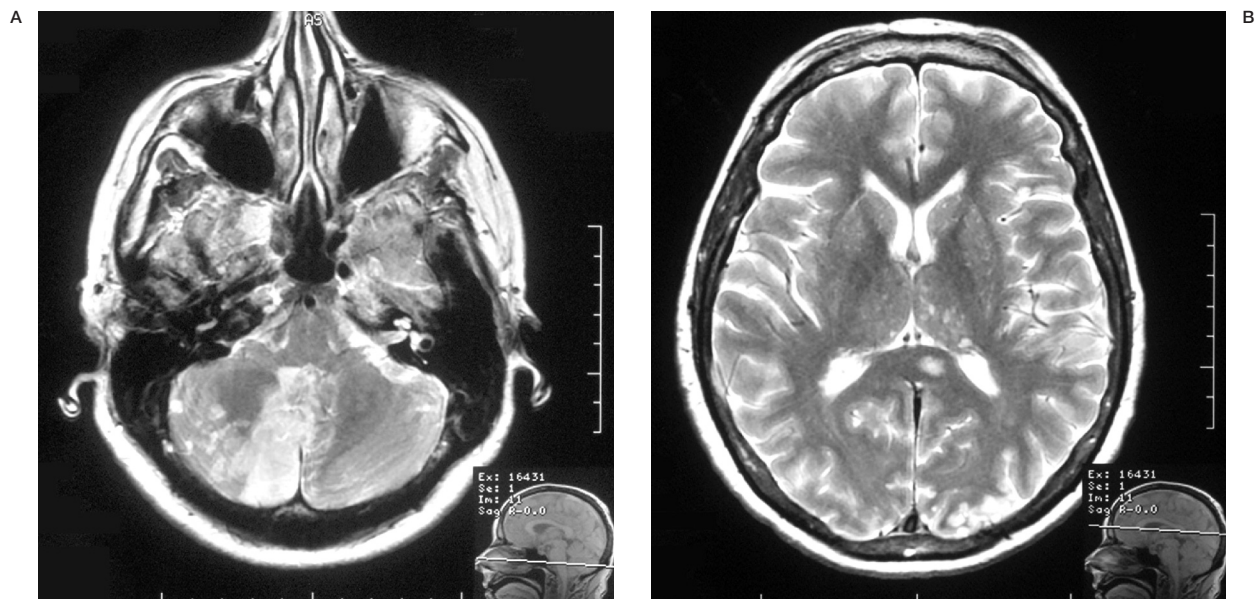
A,B) T2W axial MRI shows a focal infarct in the right medial inferior cerebellar hemisphere and multiple small hyper intense foci in bilateral thalami. The appearance is consistent with the reflux of particles in posterior circulation.
